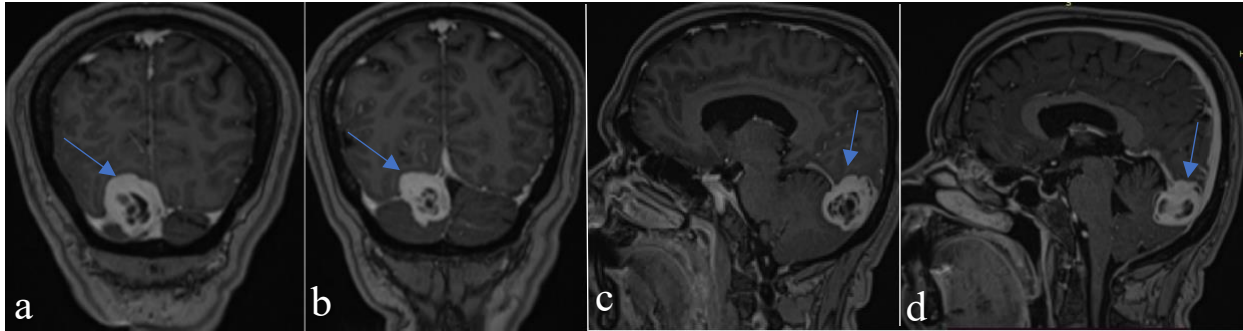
pre-surgery MRI showing the right occipital lesion and invasion of the torcula in coronal (a+b) and sagittal (c+d) T1-gadolinium sequence (blue arrow)
